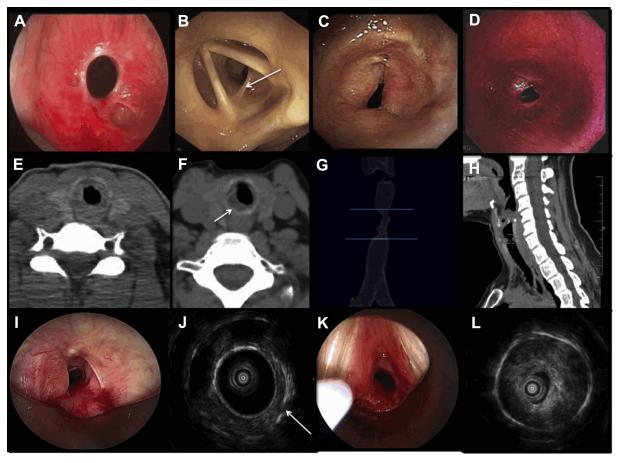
Morphologic types of benign tracheal strictures at bronchoscopy, CT, and balloon-based radial probe endobronchial ultrasound (EBUS). A, Elliptical idiopathic subglottic stricture. B, Eccentric subglottic stricture from granulomatosis with polyangiitis (arrow points to the stenotic tissue). C, Triangular (pseudoglottic) stricture after tracheostomy. D, Circumferential postintubation, simple (ie, weblike) stricture. E, Circumferential stricture (axial plane). F, Eccentric stricture (axial plane; arrow points to the hypertrophic stenotic tissue). G, Complex postintubation stenosis at three-dimensional reconstruction CT. H, Simple (< 1 cm in vertical extent), idiopathic stricture measured on sagittal CT image. I, Postintubation stenosis with hypertrophic stenotic tissues covering the cartilage. J, In the same patient, balloon-based radial probe EBUS reveals the calcified and fractured tracheal cartilage (arrow). K, Idiopathic subglottic stricture with hypertrophic stenotic tissues covering the cartilage. L, In the same patient, balloon-based radial probe EBUS reveals the intact cricoid cartilage (hyperechoic circular line).
